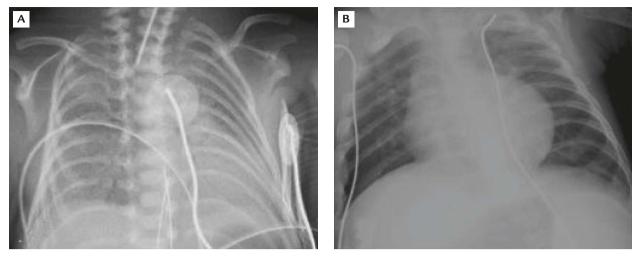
Chest X-ray films for the premature infant: (A) appearance of ground-glass pattern at 1 day of age; (B) cardiomegaly and chronic lung disease at 150 days of age.
